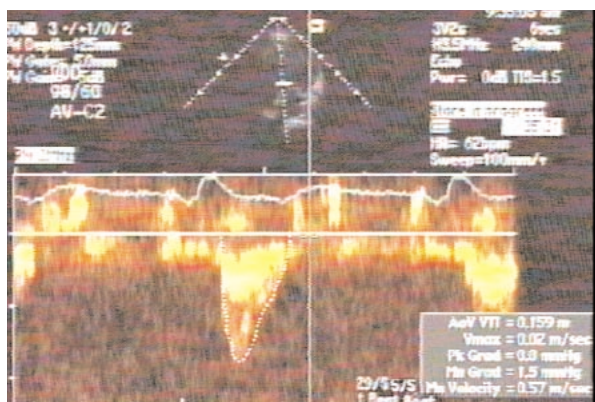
Doppler Profile Mitral Inflow—Effects of Varying AV Interval During Resynchronization Therapy. See text.
